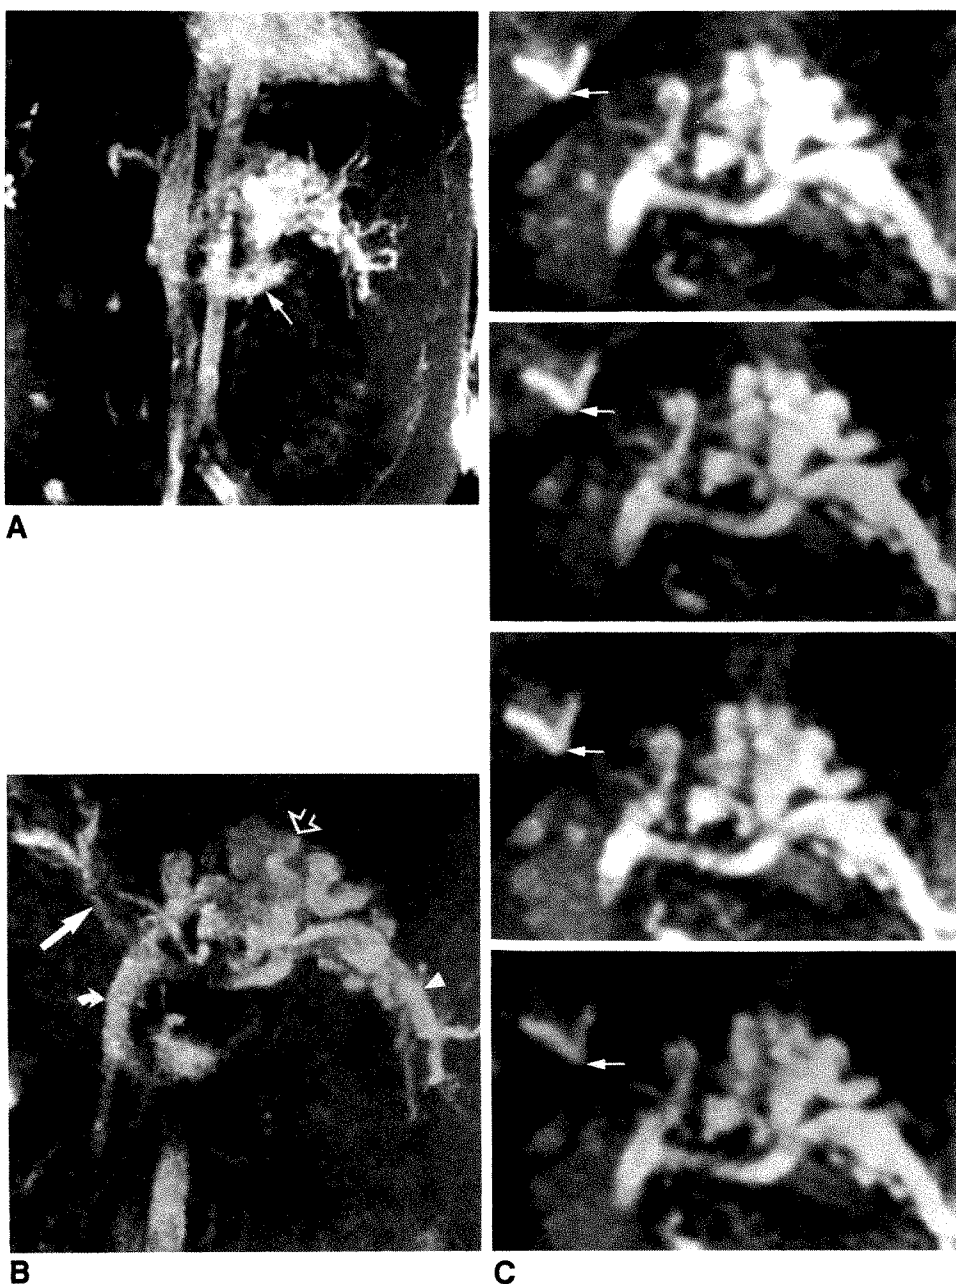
Patient with cirrhosis and portal hypertension. Thrombosis of portal vein was suspected on initial duplex sonographic examination.
